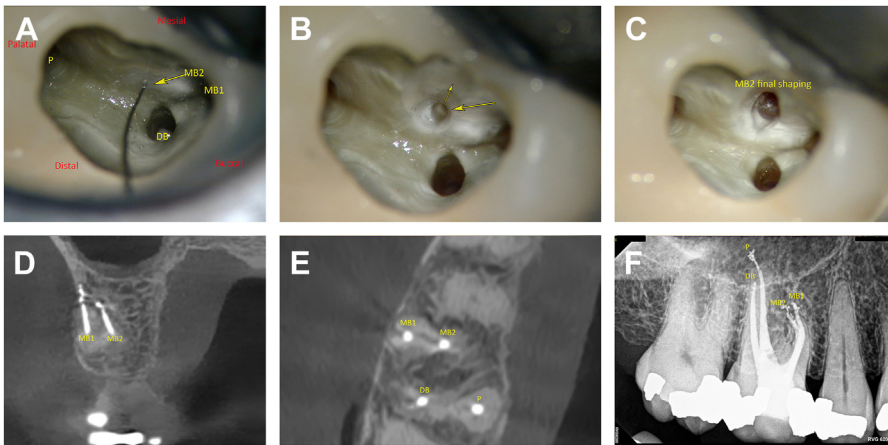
Discovery and treatment of a second mesiobuccal (MB2) canal system in the right maxillary first molar (A) Initial MB2 canal orifice discovery with a 60-micron diameter endodontic file after cleaning and shaping of the larger first mesiobuccal (MB1), distobuccal (DB), and palatal (P) root canal systems. (B) Mesial extension (arrows) of the access cavity preparation to allow deeper file entry into the MB2 canal. (C) Final extension and completed cleaning and shaping of the MB2 canal. (D) Coronal CBCT showing the MB1 and MB2 roots with separate apical portals of exit. (E) Axial CBCT through the tooth's mid-portion, showing the 4 filled canals at that level. (F) Post-treatment periapical radiograph showing completed treatment with a 3-dimensionally filled root canal system.
